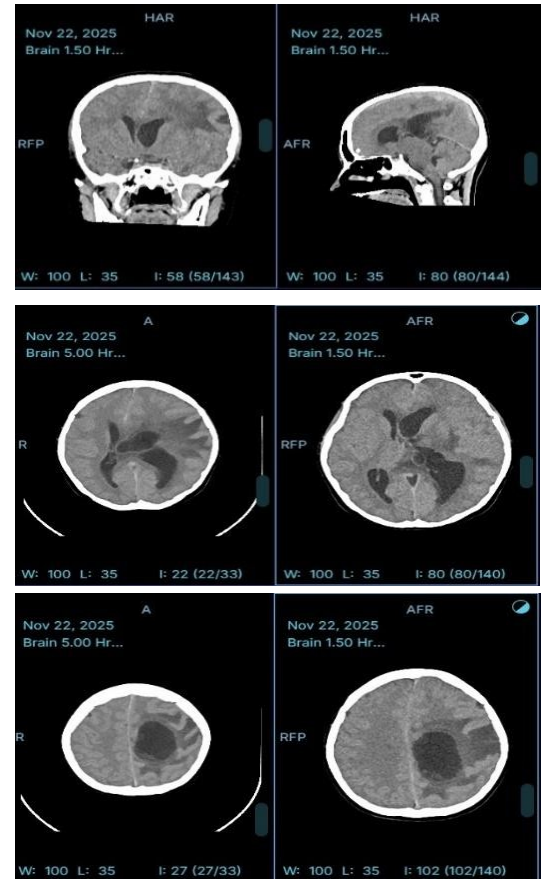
CT scan dated November 22, 2025
